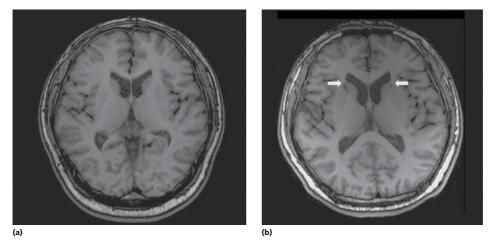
T1-weighted coronal MR images before (a) and after (b) undergoing anterior capsulotomy. Arrows in (b) indicate bilateral lesions in the mid-third of the anterior limb of the internal capsule. Source: From Zhan *et al.* [164]. Reproduced with permission of Elsevier.
